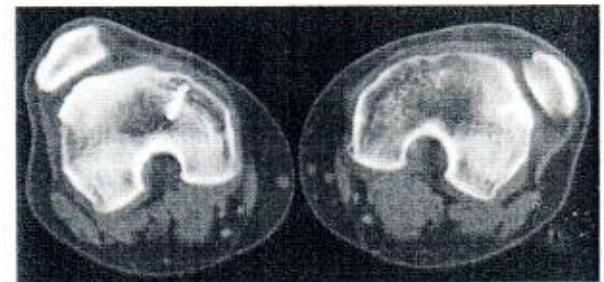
Transaxial CT of the patellofemoral joint in 16-year-old male with congenital patellar displacement who had previously undergone surgery on the right knee. In addition to the large outward rotation of both knees, the patient had abnormal anteversion angles of the hips
